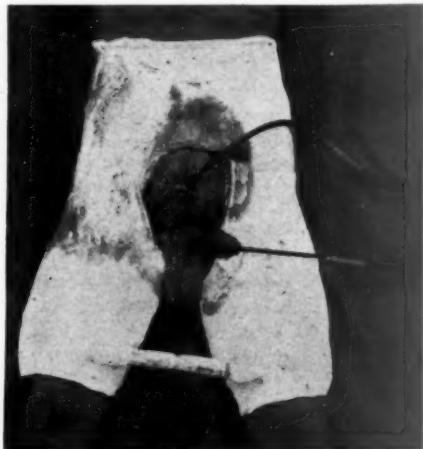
Photograph of patient whose radiograph is reproduced in Figure III, showing management in plaster spica.
